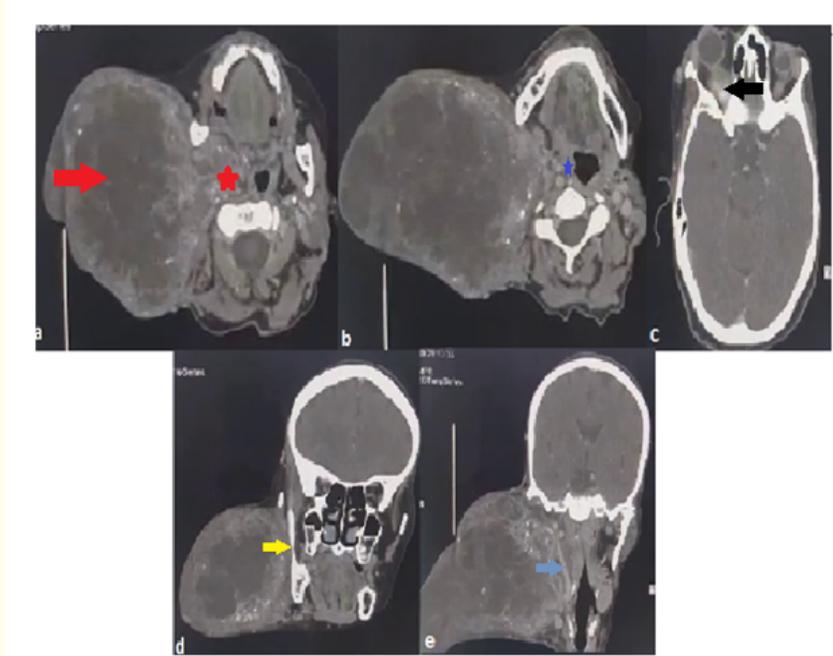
Contrast enhanced axial (a, b, c) and coronal (d, e) soft tissue window CT showing the mass involving the right parotid gland with an infiltration of parapharyngeal space and an extension to the retro-orbital space.
